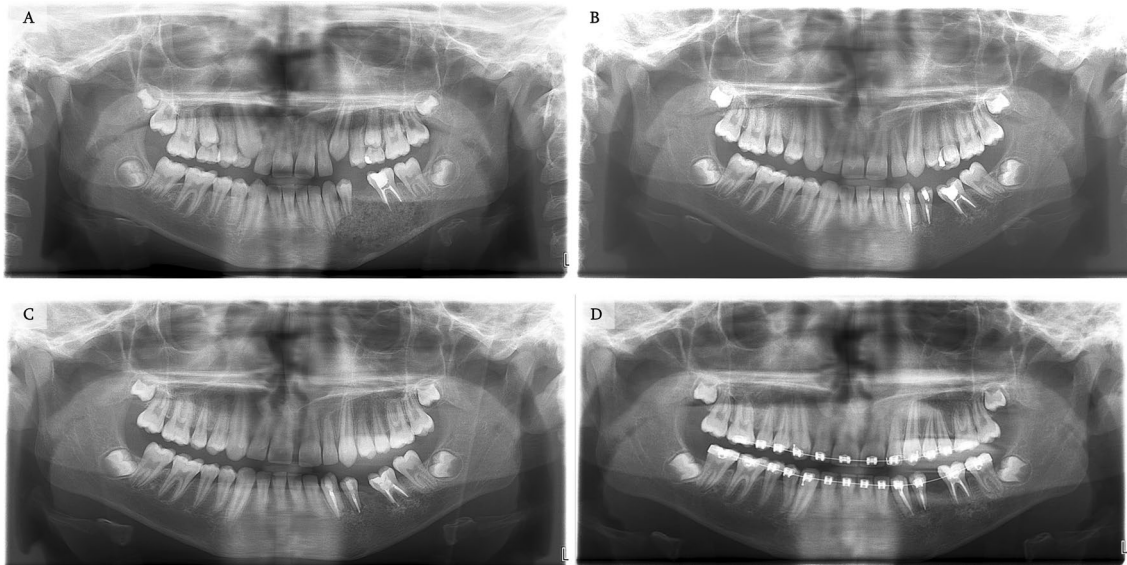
Panoramic radiographs of the treatment and follow-up course of the patient described in Fig. 11. A Immediate post-surgical treatment comprised of a partial ostectomy and excision of the aggressive
